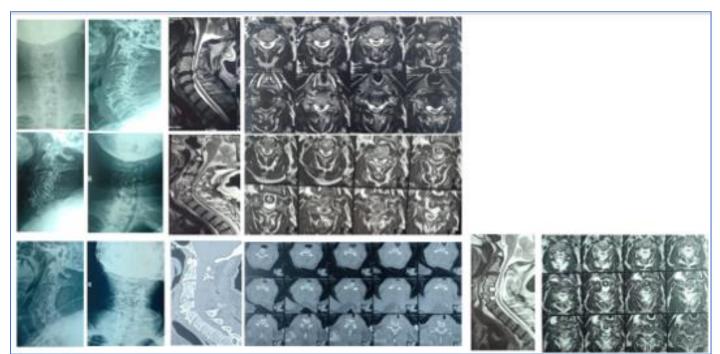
Male 58 y old with CSM, Preop VAS score for axial pain was 6 and preop JOA score was 9. (a & b) preop X Ray cx sp and (c., d.) MRI cx sp sagittal and axial views revealed C4-5, 5-6 CDP causing ant cord compression and buckled ligamentum flavum causing posterior compression at these levels. ACDF was done but the patient deteriorated neurologically. (e., f., g., H.) postop X ray cx sp and MRI cx sp; revealed cord compression and stenotic canal. After 3 days, in a second sit, PCL was done. (j., k., L., m., n., o) postop X ray, CT, MRI cx sp after the second sit, revealed good decompression. The patient was improved neurologically with physiotherapy and neurotrophic drugs. At the final follow up, VAS score improved to 2 and JOA score improved to 13.
